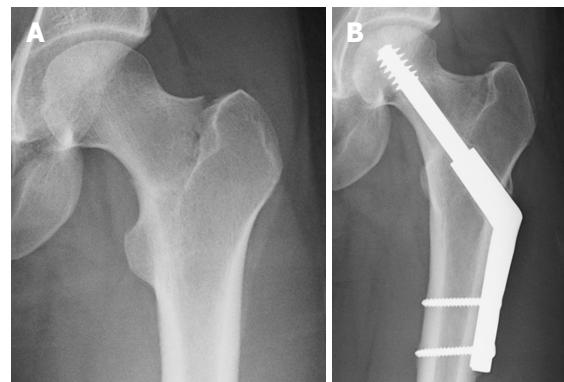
The management of a minimally-displaced tension sided femoral neck stress fracture. A: Pre-operative antero-posterior radiograph; B: Post-operative antero-posterior radiograph.
